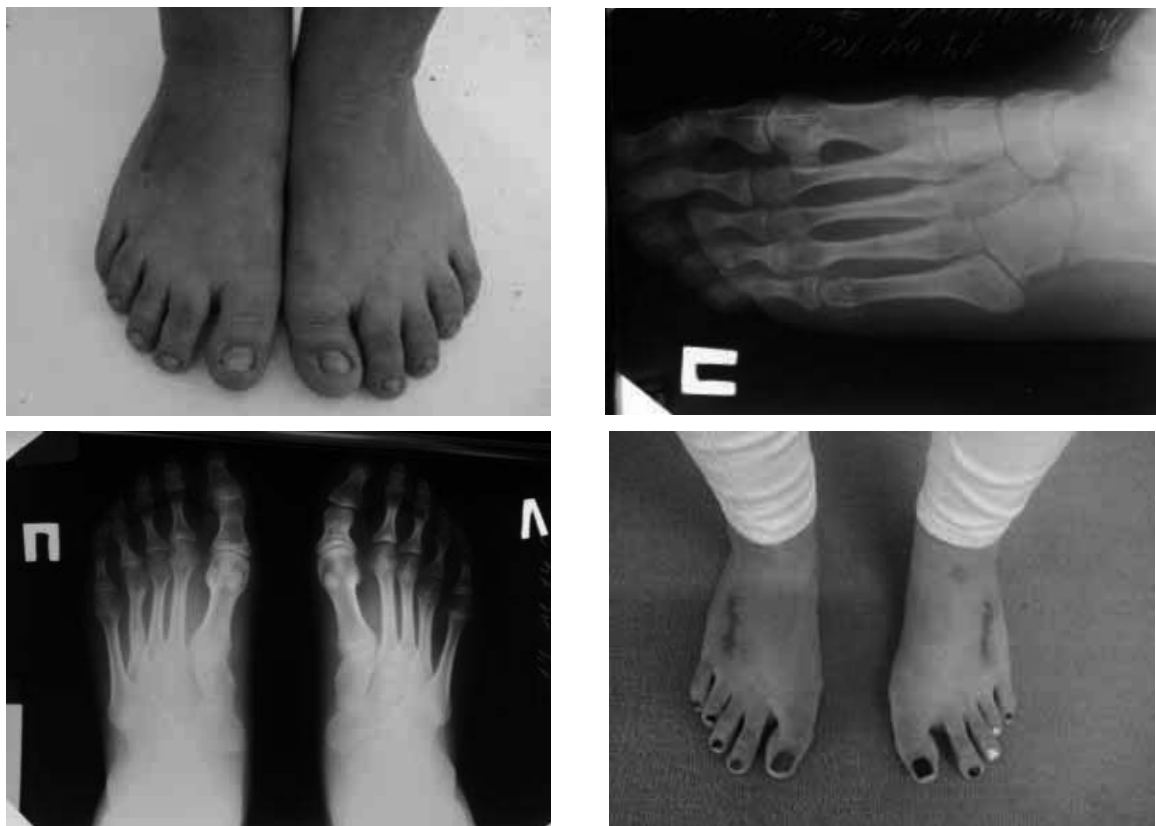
Post-operative (18 month) photographs and radiographs
